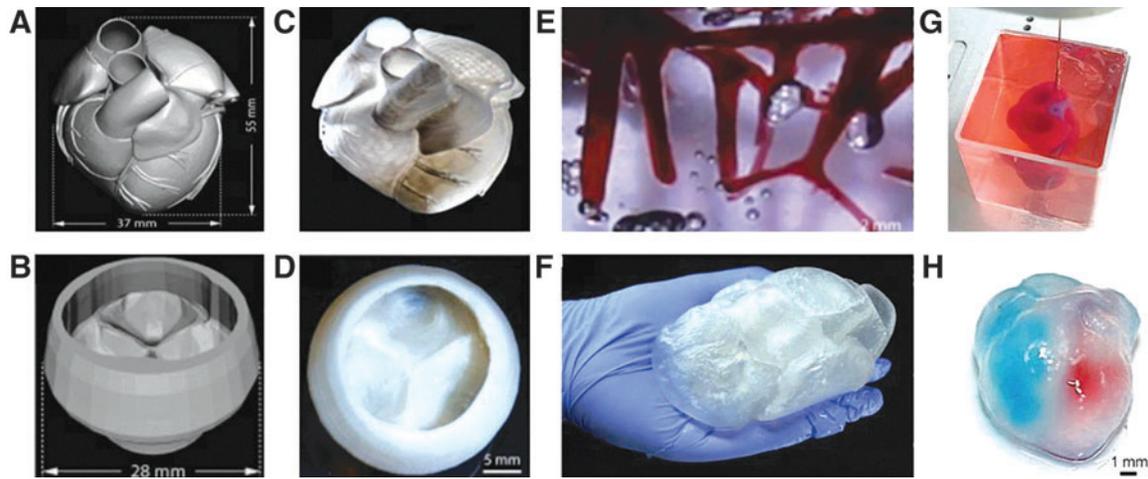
3D printing into support material (A, B) CAD-generated renderings of cardiac structures used for FRESH v2.0 3D printing.¹⁴⁵ (C, D) FRESH v2.0 printed neonatal scale human heart exhibiting complex cardiac morphology and adult size tri-leaflet heart valve, respectively.¹⁴⁵ (E) FRESH v2.0 printed construct based on MRI-derived CAD rendering of the left anterior descending artery with computationally generated microvasculature capable of perfusion.¹⁴⁵ (F) FRESH v2.0 printed full-size adult human heart.¹⁴⁶ (G, H) Heart containing independent chambers, vasculature, and imbedded CMs and ECs printed into alginate microparticle support bath.¹³⁸ FRESH, freeform reversible embedding of suspended hydrogels.
